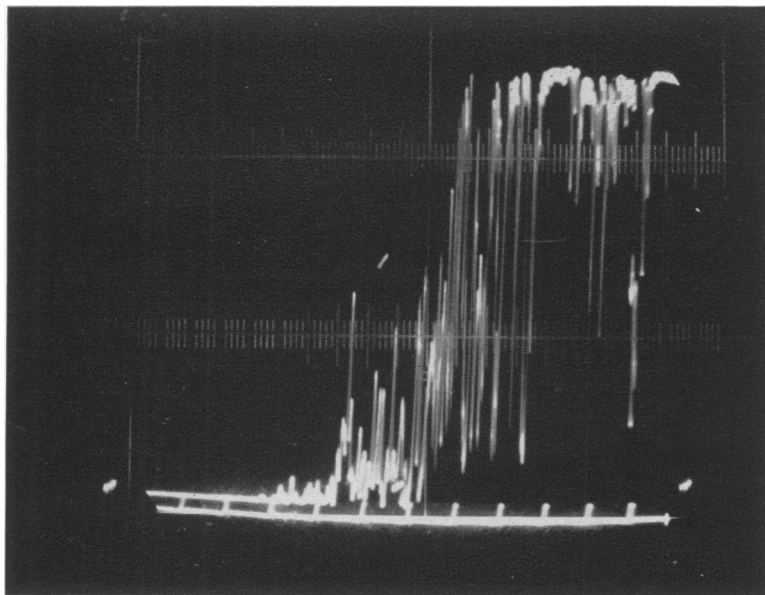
A characteristic ultrasound pattern obtained over an area of embolized lung in the same patient as Fig. 1. Echoes increase markedly in prominence and depth as the transducer is placed over a portion of ischemic lung.
